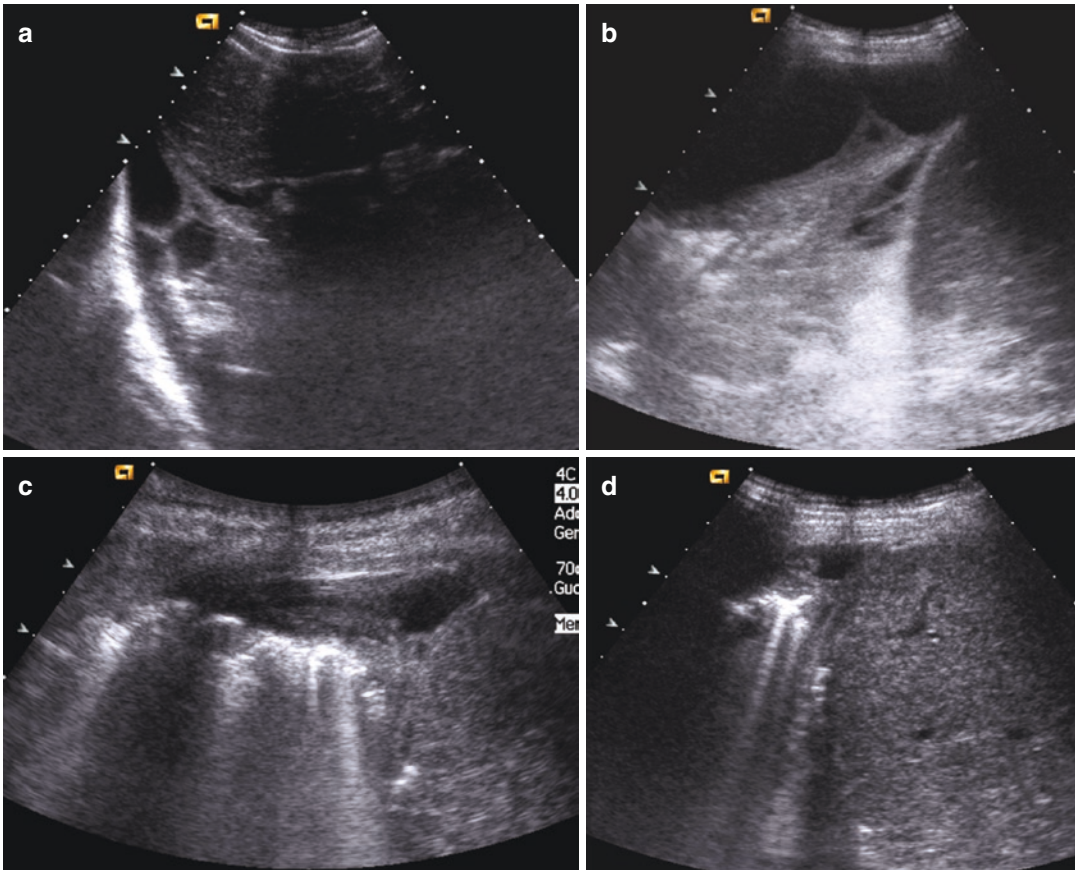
Lung ultrasound. Defenestration, follow-up examinations: (a) and (b) sonographic signs of septations and pluri-concamerated anechoic areas, suggestive of retained hemothorax; (c) and (d) after 1 month, resolution
